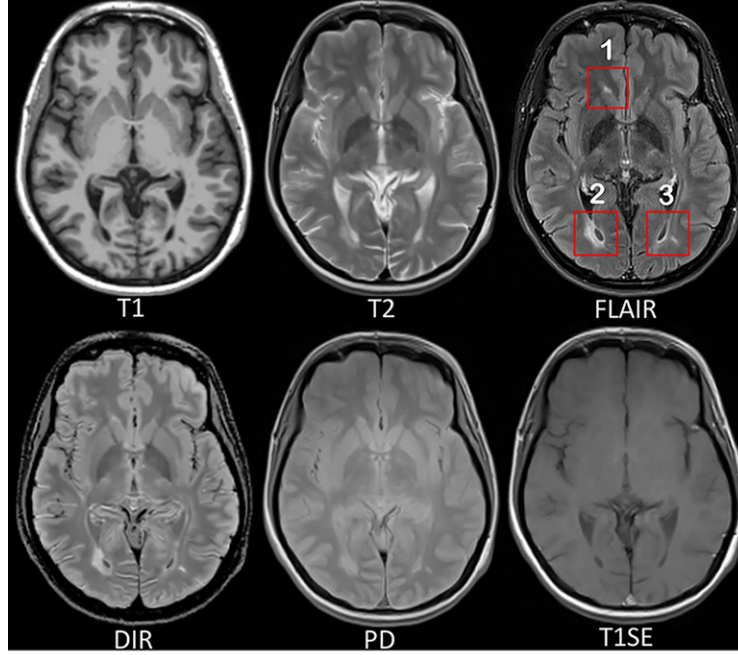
MRI pulse sequences usually used in a clinical setting.
